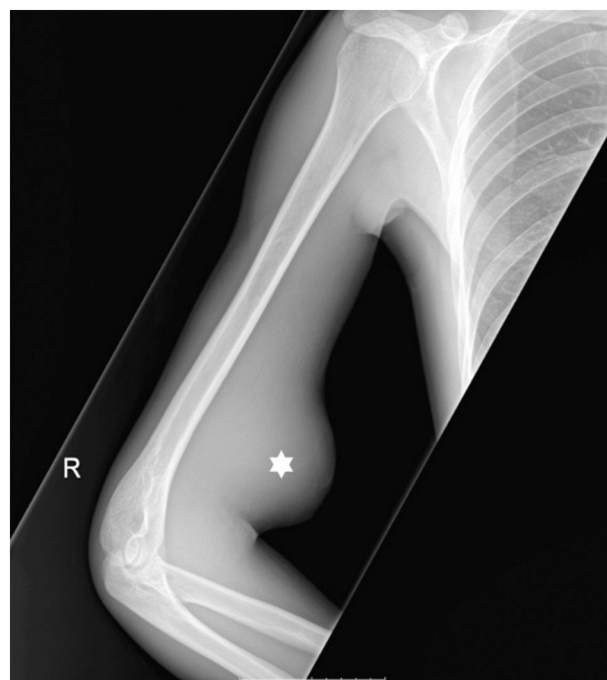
Lateral right arm radiography showing hyperdense soft tissue swelling (star) separate from bone.
